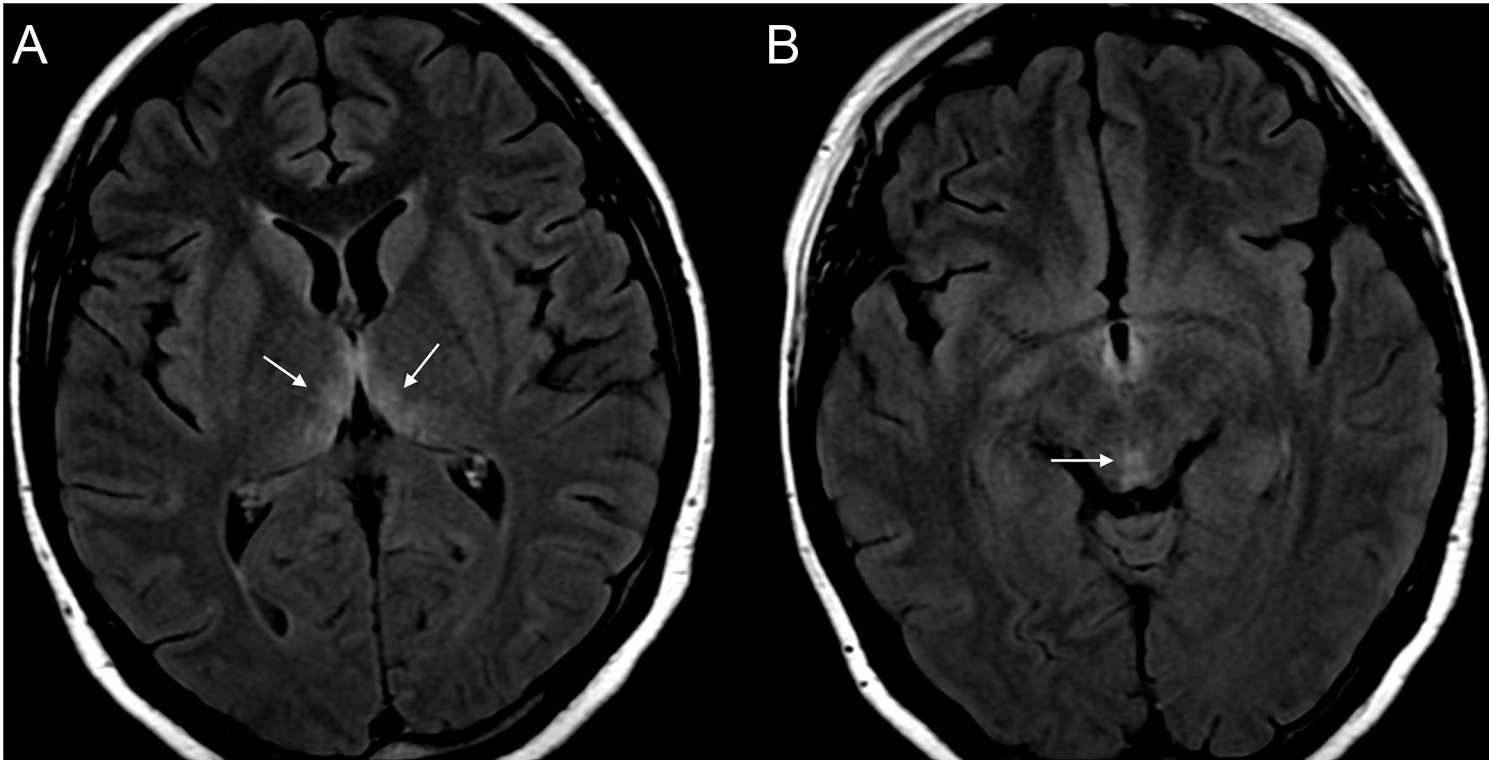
Axial FLAIR (fluid attenuation inversion recovery) depicting increased signal intensity in the medial part of the thalami (A) and periaqueductal white matter (B).
